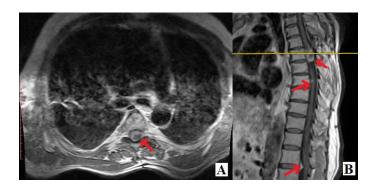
Lumbar and thoracic MRIs of a 66-year-old male patient who experienced back pain for 2 years. The patient has a history of T4 laminectomy 20 years ago and biopsy for suspected prostate carcinoma but the biopsy revealed no carcinoma cells. No history of neurofibromatosis type 2 was known. A) Axial C+T1WI sequence of thoracic MRI revealed heterogeneously enhanced intradural extramedullary hypointense lesion at the T5 level that was compressing the left side of spinal cord. B) Sagittal C+T1WI sequence of thoracic MRI revealed multiple involvements of intradural extramedullary lesion on the T5, and lesion at the T7 and T12-L1 levels that was suspected to be metastasis. He underwent NTR of an intradural lesion at the T5 level with a laminectomy. The lesion was confirmed to be a meningothelial meningioma WHO grade I. After physical therapy rehabilitation, the patient was doing well without recurrence. Red arrows indicate multiple lesions
